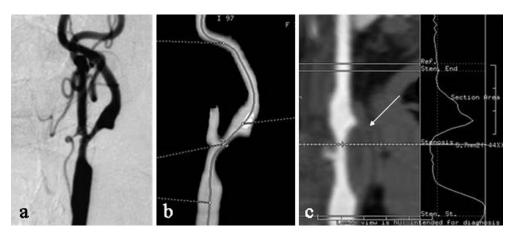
Conventional digital subtraction angiography (DSA) (a) demonstrates stenosis at the left carotid bifurcation. The same lesion was excellently revealed on CT angiography (CTA) with 3D image (b) and lumen image (c) produced by 3D CTA analysis software. The lumen image (c) also shows the plaque (*arrow*). The analysis software also automatically defines the level of maximal stenosis.
